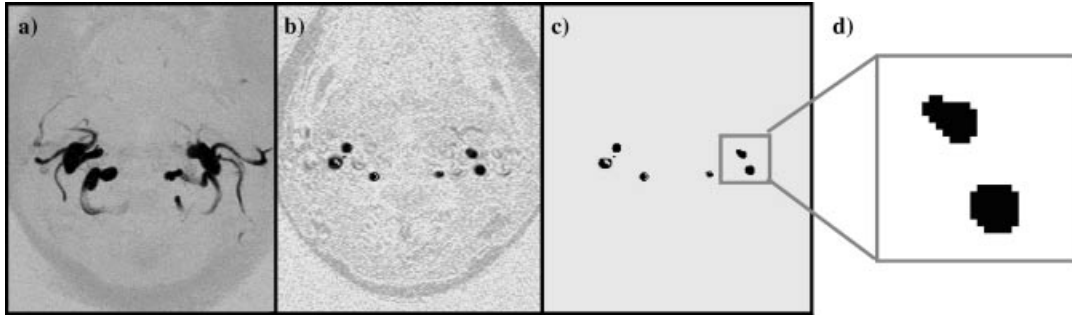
CTA image processing: (a) MIP of the original 3D image; (b) original middle slice ($z=25$); (c) middle slice after sharpening; (d) detail of middle slice after region growing segmentation of the left carotid artery.
